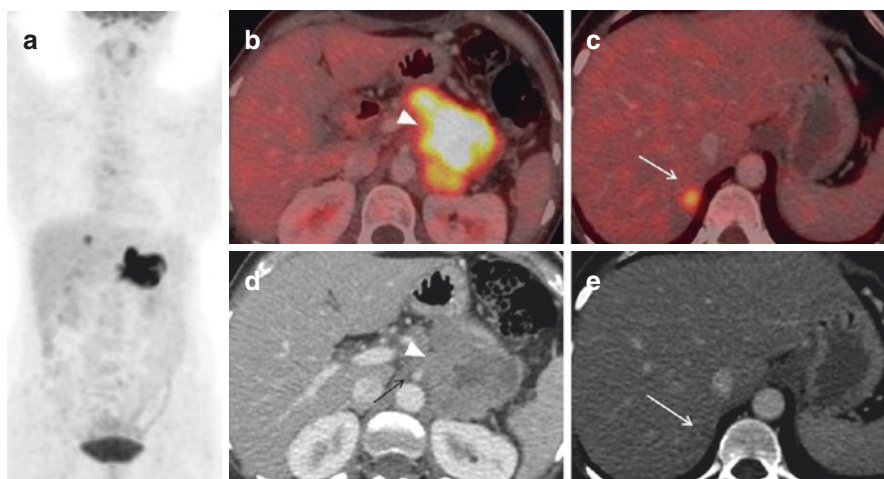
FDG PET/CT in staging of pancreatic adenocarcinoma: MIP image (a) shows large area of tracer concentration in the mid-abdomen with focal tracer uptake in the liver. Axial PET/CT (b) shows FDG-avid large soft tissue mass in the body of pancreas with encasement of superior mesenteric artery on venous phase CT component (c-arrow) of PET/CT. There is intense desmoplastic reaction (c-arrowhead) with FDG uptake (b) delineating the actual tumor. Axial PET/CT (d-arrow) shows FDG-avid lesion in the liver which is seen as subtle hypodensity on CT (e-arrow) image suggestive of metastatic involvement
